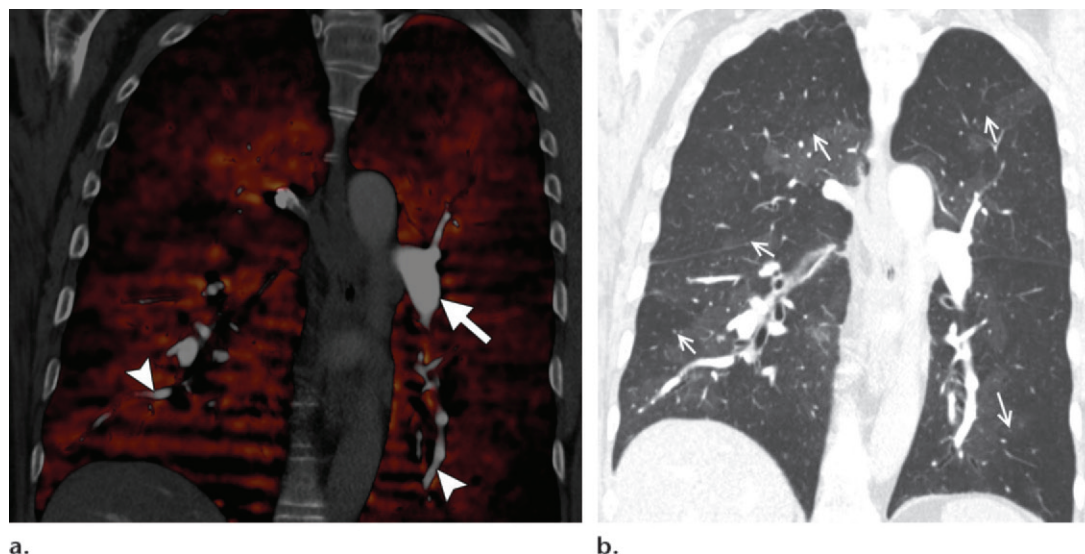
Peripheral perfusion defects beyond the resolution of CTPA in a 73-year-old woman with CTEPH. (a) Coronal fused PBV image shows several small peripheral perfusion defects at both lung bases, including very small defects at the right lung base that would be beyond the resolution of perfusion scintigraphy. Note the absence of filling defects in the central (arrow) and peripheral (arrowheads) pulmonary arteries. This likely reflects perfusion defects beyond the resolution of CTPA. (b) Coronal mixed (100-kVp and Sn 140-kVp) lung-window image shows bilateral mosaic lung attenuation (MLA), with areas of reduced attenuation (arrows) that closely reflect the perfusion defects seen on the PBV image.
